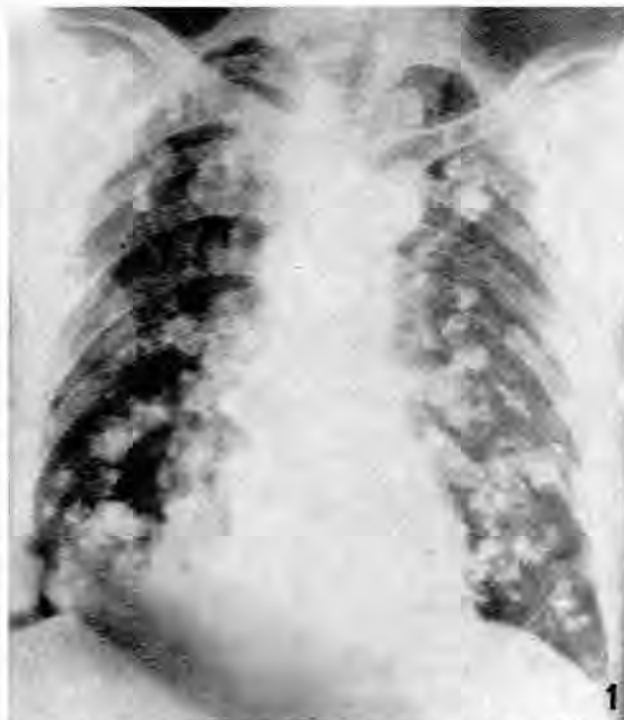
Chest X-ray showing calcified masses in both lung fields.
